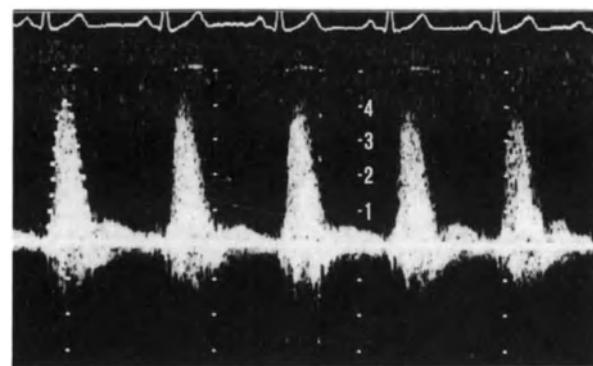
This continuous wave Doppler trace was recorded from the suprasternal notch in a patient with severe aortic valve stenosis. The peak jet velocity is 4m/s, which can be used in the modified Bernoulli equation to give a calculated peak instantaneous valve gradient of 64 mm Hg.
